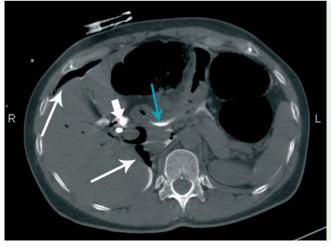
Patient 1: computed tomography (CT) scan depicting free air in peritoneal cavity and retroperitoneum (long white arrows), fluorescent contrast leakage around the duodenal wall (blue arrow) and a stent in the distal common bile duct (short white arrow).
